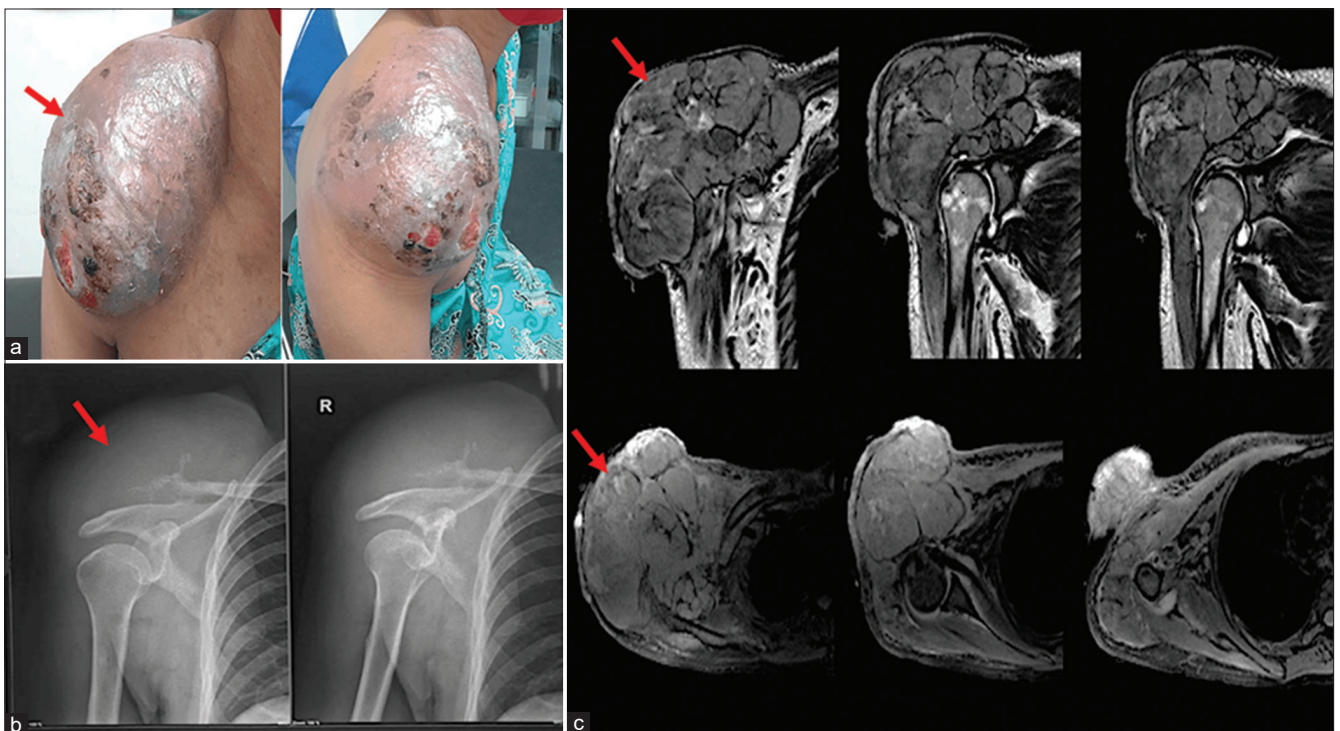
Clinical and radiology features of the patient. (a) Solid, fixed, and ill-defined border mass of the right shoulder, approximately $20 \times 15 \times 10$ cm. (b) Shoulder X-ray revealed soft-tissue mass of the right shoulder region with the destruction of lateral part of the right clavicle. (c) MRI revealed a solid mass that arose from soft tissue of subcutis, infiltrating the trapezius, and proximal part of the deltoid muscles
